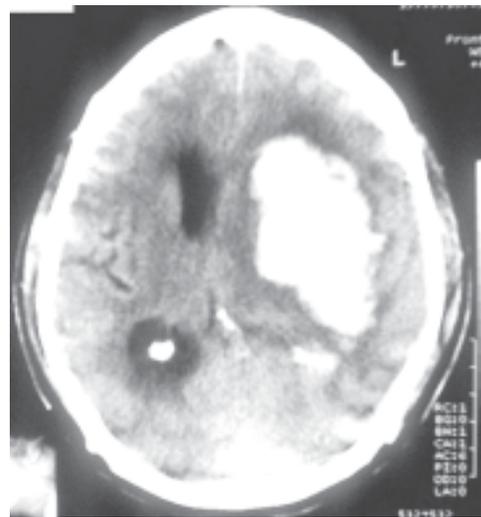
Plain CT scan showing left basal ganglion ICH with frontoparietal extension
